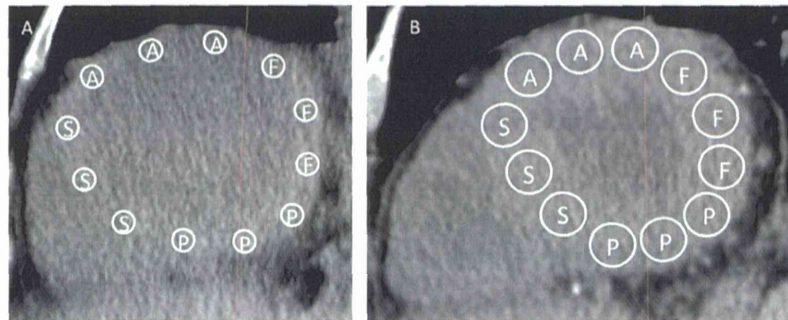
Antemortem and postmortem CT images of the heart in a representative patient. A: Multiplanar reconstruction image obtained by antemortem CT. B: Multiplanar reconstruction image obtained by postmortem CT. Both images were obtained in same plane. A, anterior wall of the left ventricle; F, left ventricular free wall; P, posterior wall of the left ventricle; S, ventricular septum.
